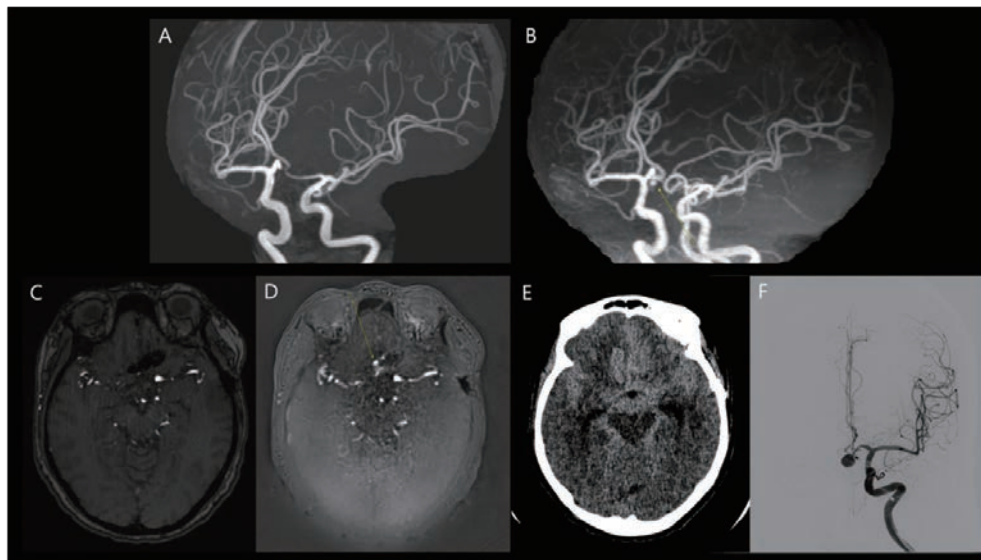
A 9.5mm recurrent aneurysm at the anterior communicating artery (ACOM) was detected on PETRA-MRA (B, D), but was not visualized in previous and concurrent TOF-MRA (A, C) due to metallic artifact. Even though the patient was recommended an elective embolization, the patient did not follow up. 3 years after the MRA, the patient presented to the emergency room due to severe headache, for which emergency brain CT revealed extensive subarachnoid hemorrhage (E). The patient had to undergo emergency embolization of the recurrent aneurysm but has remaining sequelae (F).
